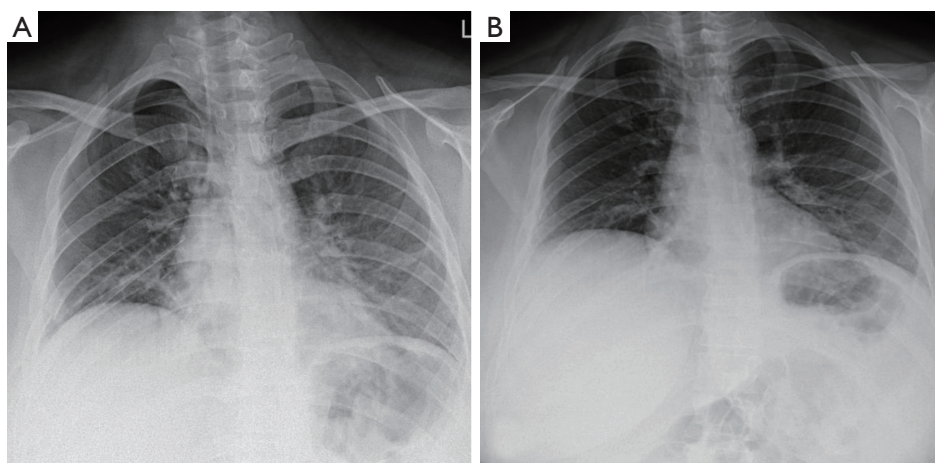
Chest X-ray of patient 3. (A) after thoracostomy tube placement; (B) after removal of the tube and resolution of pneumothorax.
